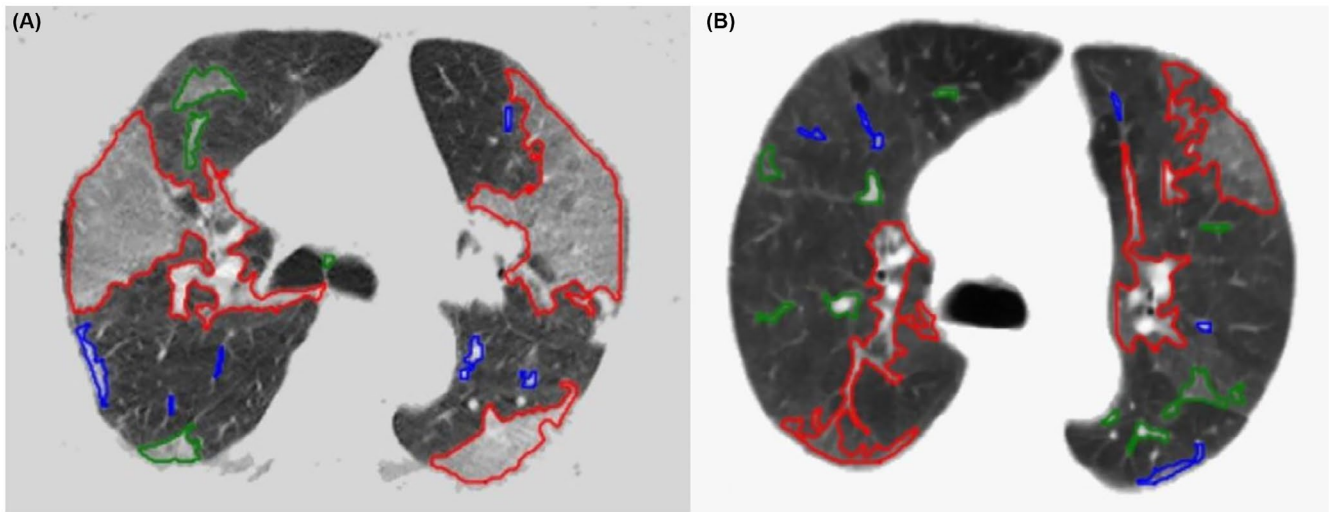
The male patient received methylprednisolone + pirfenidone treatment; Pre-treatment (A) and post-treatment (B) CT images that pass at the same level show a marked decrease in lung involvement rates
